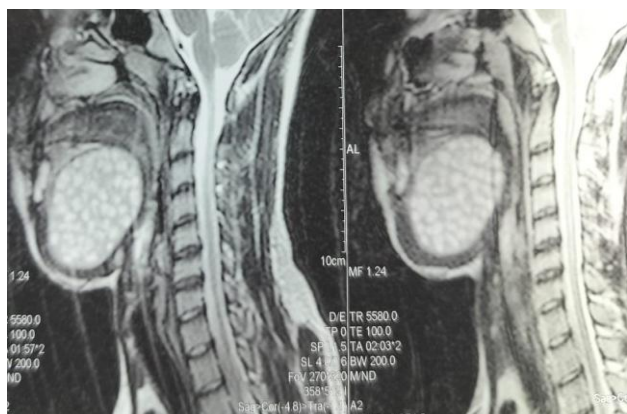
Contrast MRI neck sagittal view showed altered signal intensity lesion of size 83x80x56 mm in submental area.
